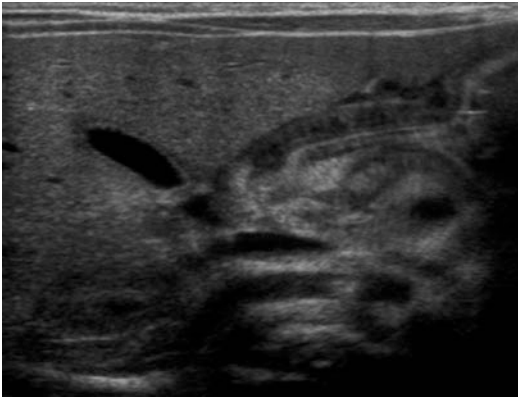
Ultrasound shows the anatomical landmarks to find the pylorus. Here you see the relationship between the pathological pylorus, which is located medially to the gallbladder and the liver
